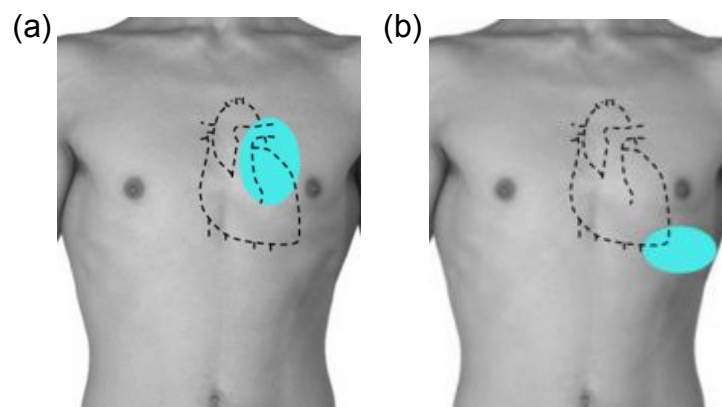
Acoustic windows at the a. parasternal and b. apical locations for imaging the adult heart. The parasternal acoustic window lies between the 3rd and 5th intercostal space left of the sternum. The apical acoustic window lies along the median axillary line in the 5th intercostal space.
